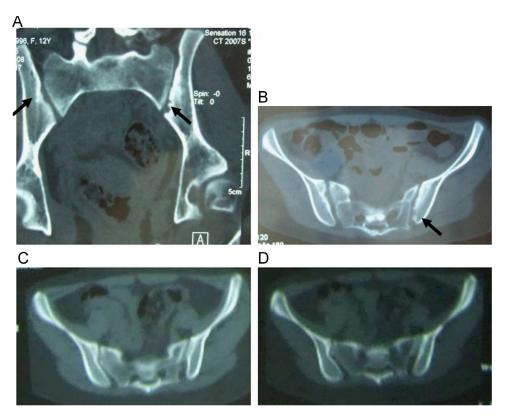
CT scan of sacroiliac joints in 2008 (A and B) showing bone erosions in the left iliac edges (arrow); repeated scan showed the erosions were repaired in sacroiliac joints in 2012 (C and D).
